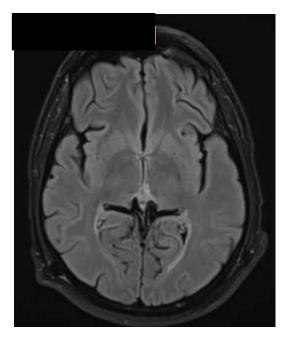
Axial section of FLAIR sequence MRI; showing clear regression of the midline lesion process centred on the pineal gland, measuring 9.7 mm x 6.6 mm x 3.2 mm.
